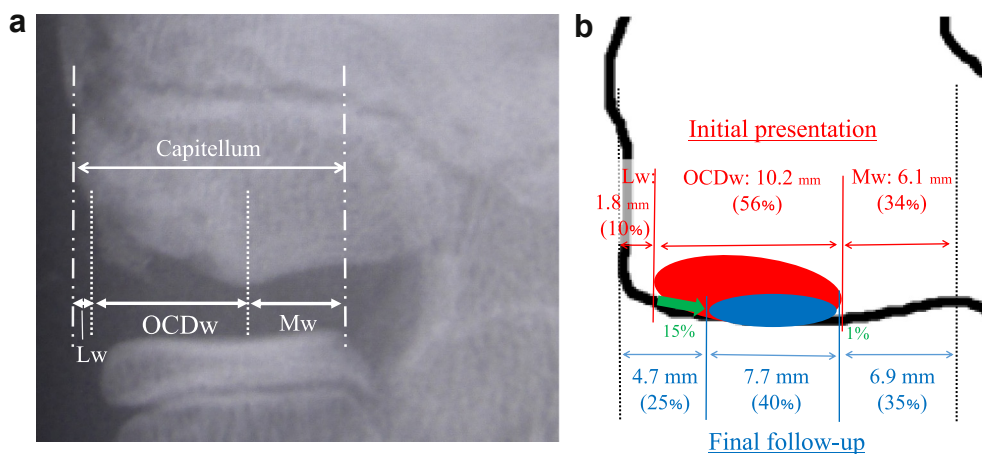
Quantitative radiographic assessment. (a) The OCD lesion width (OCDw) on an anteroposterior radiograph with the elbow at 45° of flexion was measured along a straight line parallel to the subchondral bone surface of the radial head. The lateral width of the normal capitellum (Lw) and medial width (Mw) of the normal capitellum were also measured. The ratio relative to the capitellum width was used to calculate the normalized value: normalized OCDw (%OCDw), normalized lateral width (%Lw) and normalized medial width (%Mw). (b) The results of the quantitative assessment at the initial presentation (shown in red) and the final follow-up examination (shown in blue). The changes of %Lw and %Mw are shown in green. The decrease in %OCDw was 15%. OCD, osteochondritis dissecans.
